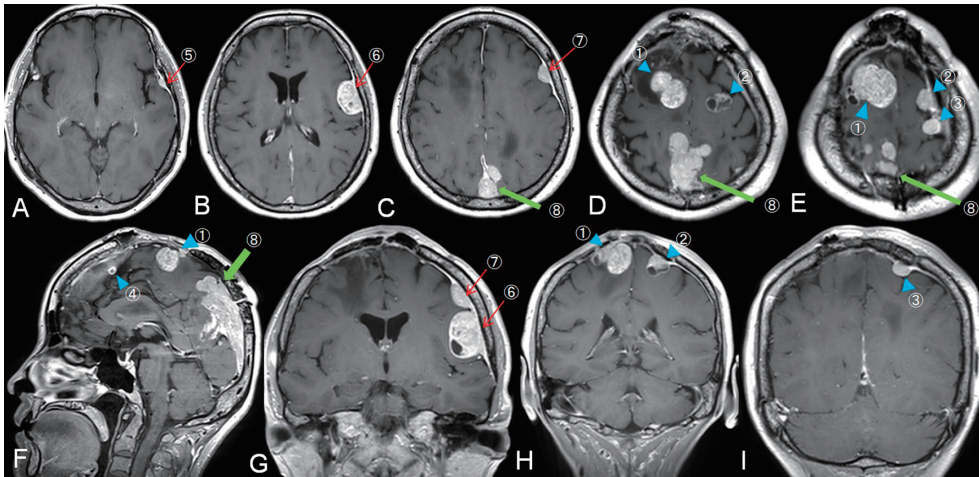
Magnetic resonance T1-weighted images with gadolinium show multiple tumors at bilateral convexity and the superior sagittal sinus (A-E : axial, F : sagittal, G-I : coronal views, tumors #1-8). The superior sagittal sinus tumor (#8) was removed at the first surgery (thick arrow). At the second surgery, frontal tumors (#1-4) were removed through bi-frontal craniotomy (arrowhead). Next, left side tumors (#5-7) were removed through a left frontotemporal craniotomy (arrow).
